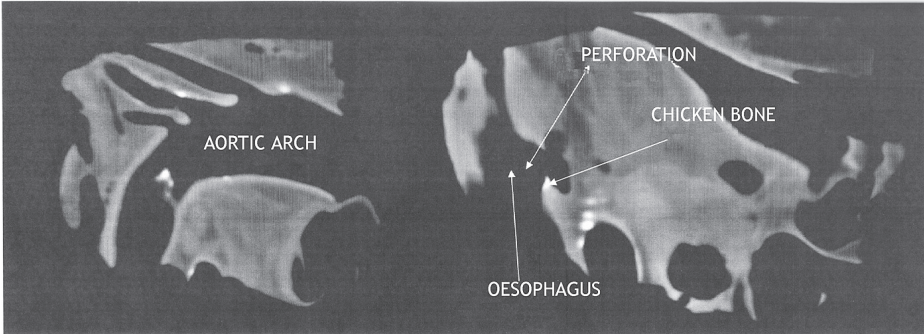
Computed Tomography findings. Esophageal perforation and a foreign body of bone density are recognizable.
